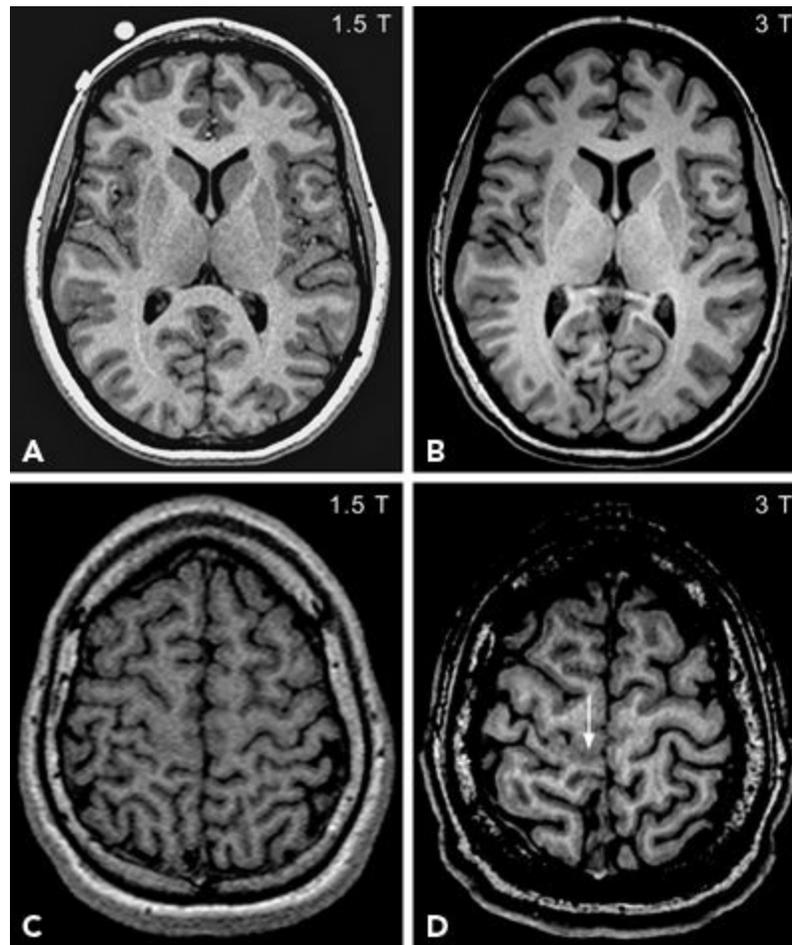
Comparison between 1.5 T and 3 T MRI (same patient). A, B: Axial MP-RAGE images with 1.5 T (A) and 3 T (B) MRIs show improved signal-to-noise ratio resulting in better gray–white contrast, on 3 T MRI. C, D: Subtle blurring of gray–white region on the banks of central sulcus (arrow), barely visible on the 1.5 T MRI (C), is better visualized on 3 T MRI (D).
